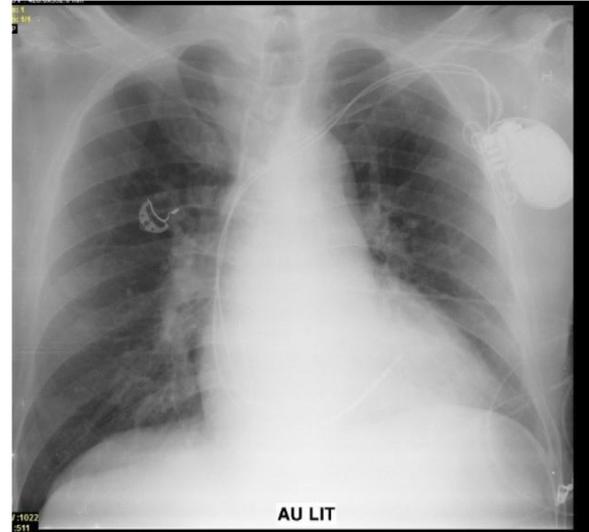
Chest X-ray showing the coiling of the device leads around the device in a 72-year-old man.
